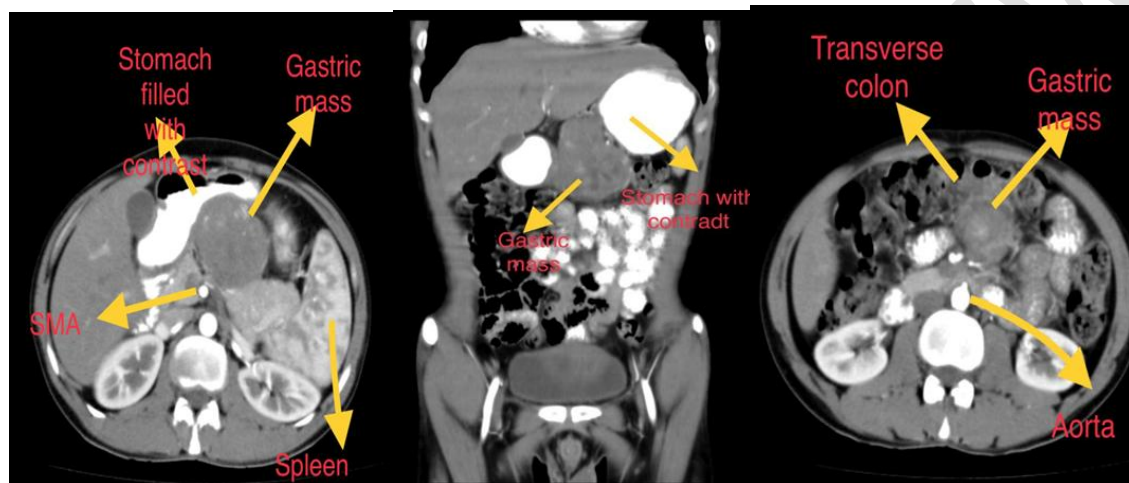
Radiological finding in the CT scan
